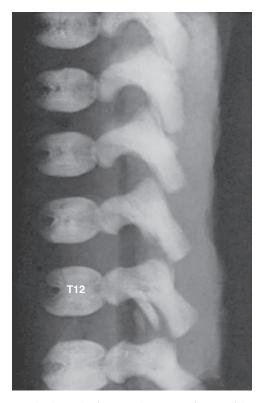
Lateral radiograph of a 34-week spine. Ossification of the centra starts first at the lower thoracic spine, working craniad and caudad from that point.
